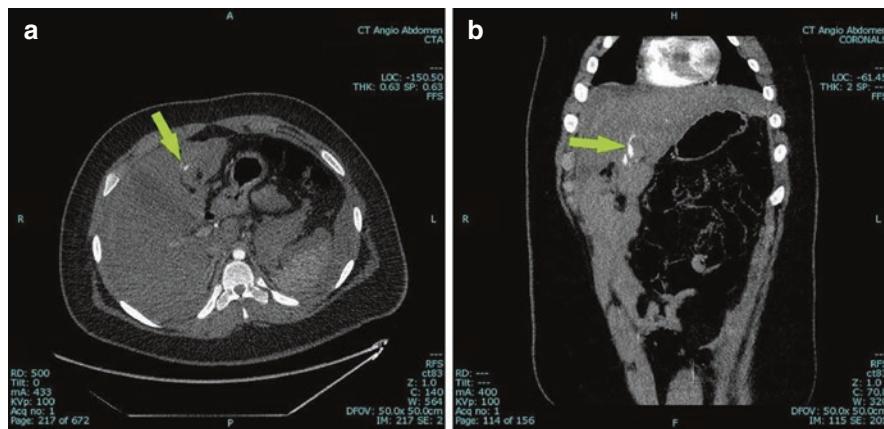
(a, b) CT abdomen images (axial and coronal views) demonstrating bleeding in the liver with green arrows indicating the contrast extravasation (Courtesy of Dr. Bhupender Yadav)
